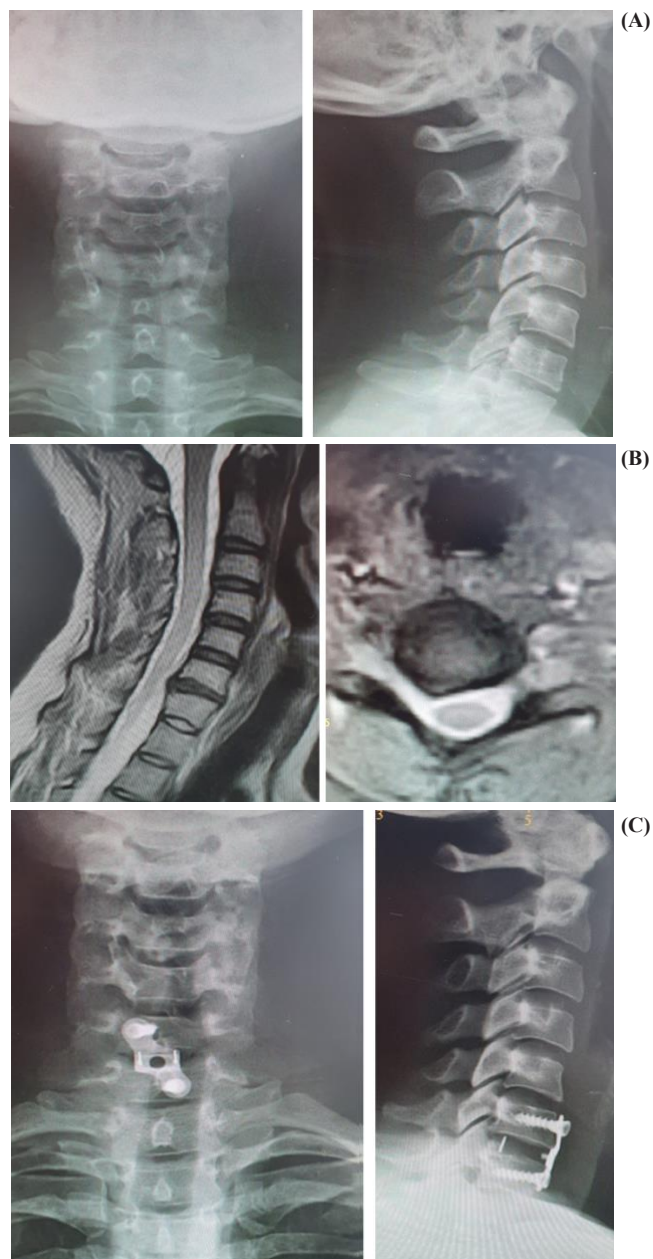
Thirty three years old female C/O neck pain and right brachialgia due to C6-7 disc herniation. Anterior cervical discectomy with PCB implant was performed. (A) Preoperative plain radiographs (B) Preoperative MRI (C) Postoperative plain radiograph at final follow up.
